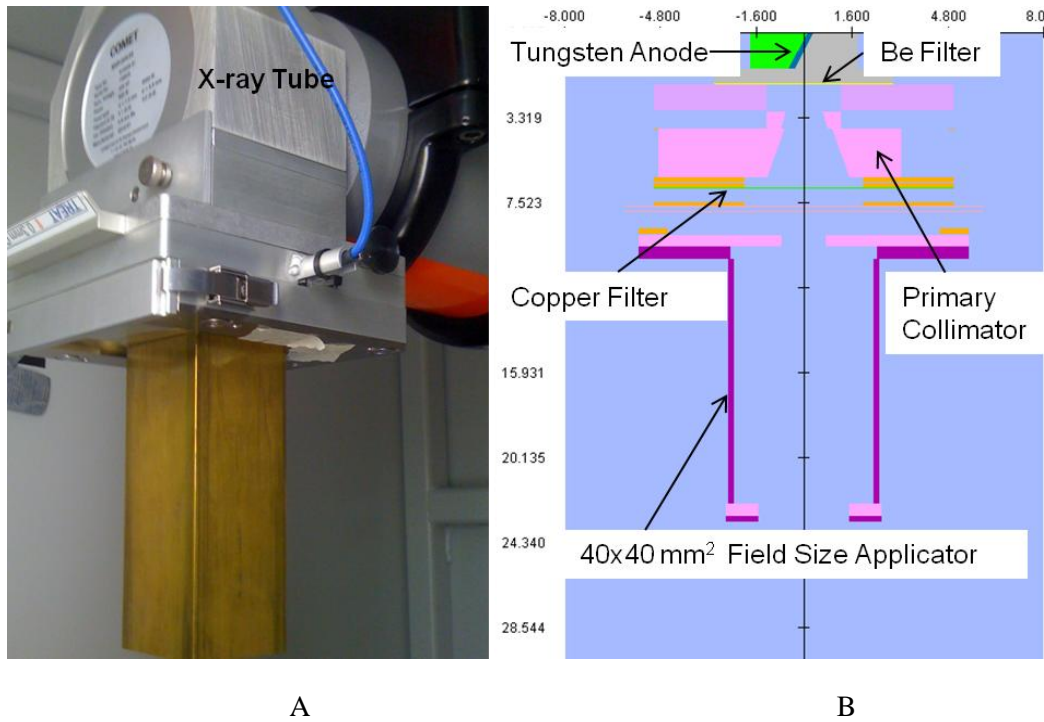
A: The x-ray therapy system inside the XRAD 225Cx irradiator enclosure. Figure 3.1 B: Monte Carlo geometric model of the components of the x-ray tube as used to generate the 225 kV photon beam. All dimensions are in centimeters. Values on the figures distances from the central axis to the inner edges of the openings, for both  $x$  and  $y$  collimators and have 0.01 cm uncertainty.
